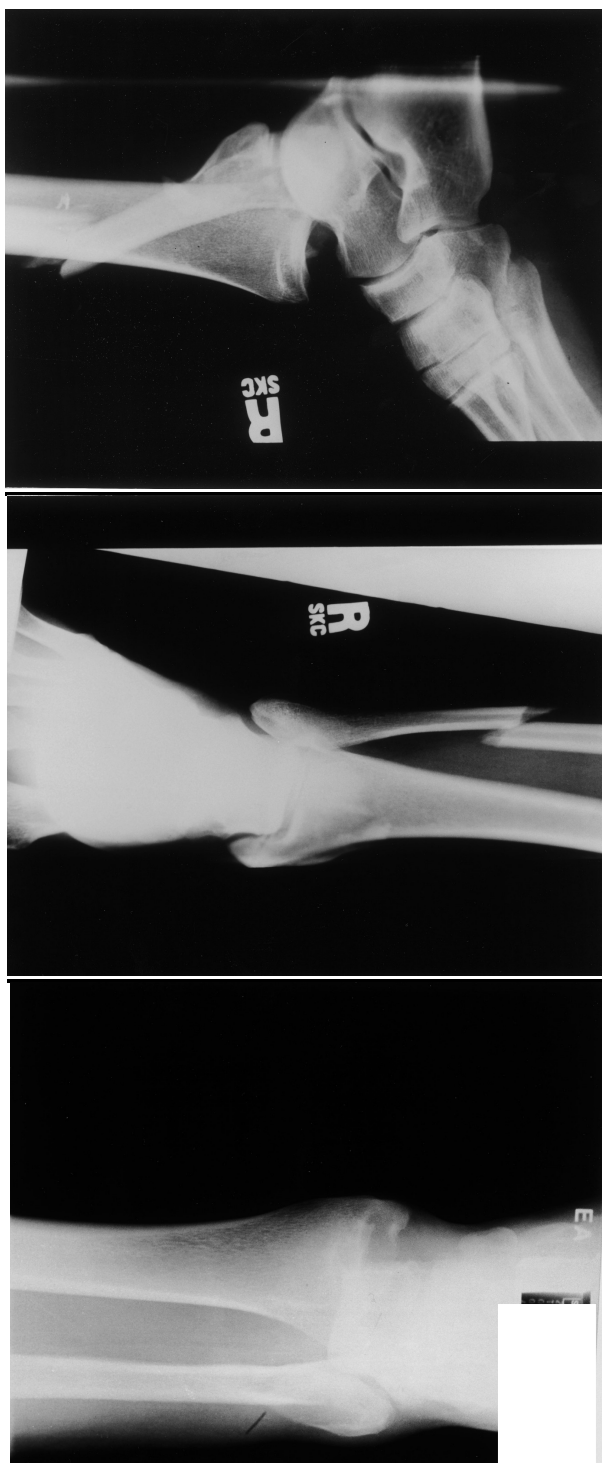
Radiographs from the PWC File 15.
